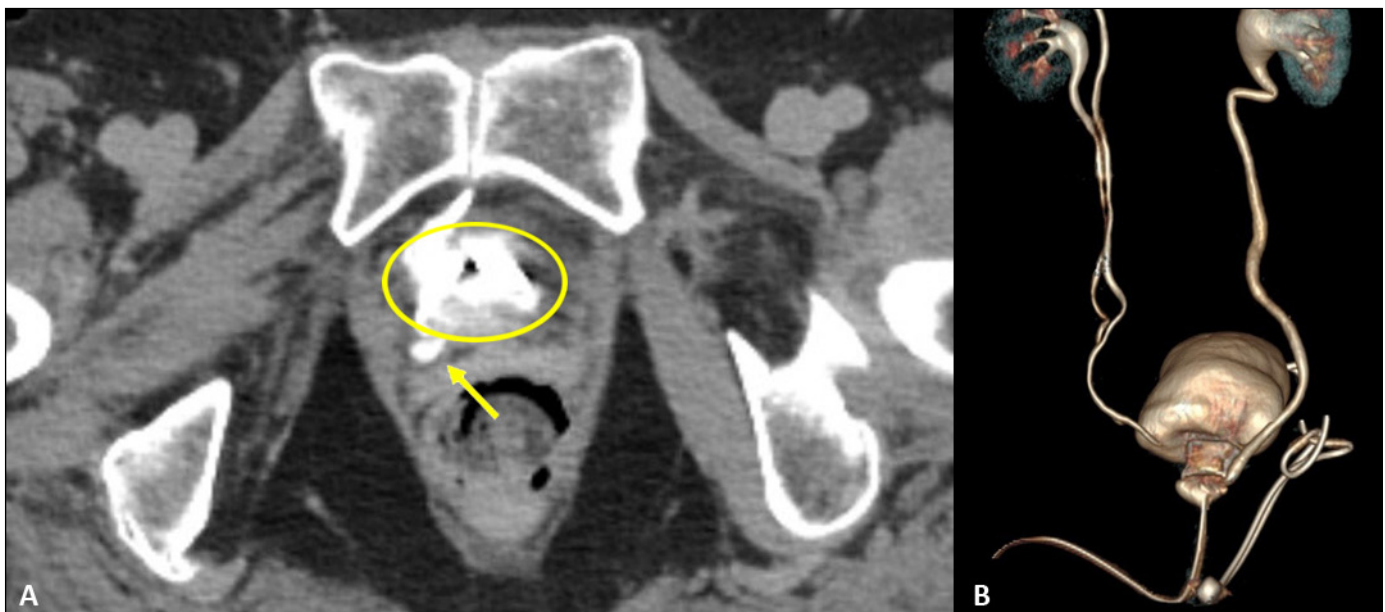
CT-urography showing right ureteric involvement in AUS cuff: A) CT-urography, tapered distal right ureter (arrow) towards the AUS cuff (circle); B) posterolateral 3D reconstruction.
